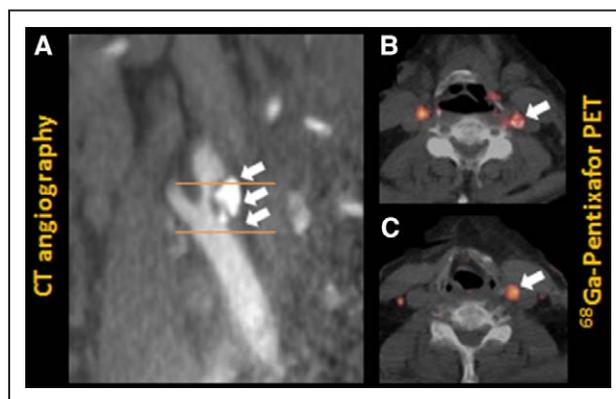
In vivo computed tomography (CT) angiography and ^{68}Ga -Pentixafor positron emission tomography (PET) in a patient with high-grade carotid stenosis. CT angiography identifies high-grade carotid stenosis due to partly calcified plaque (A). Upper calcified portion exhibits elevated ^{68}Ga -Pentixafor uptake, similar to contralateral atherosclerotic vessel wall (B). Tracer uptake in the noncalcified plaque area (C) is markedly higher than in the contralateral artery. Arrows indicate plaque. Orange lines indicate intersections.
